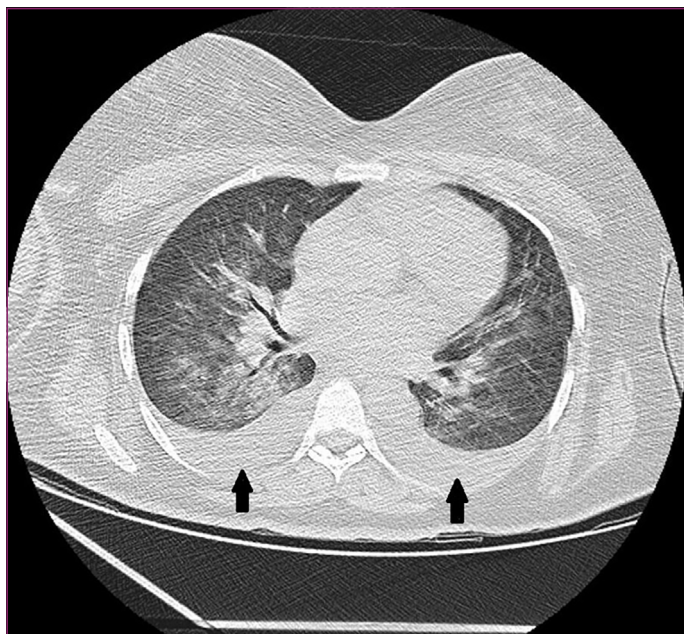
Preoperative thoracic computed tomography (CT) revealed bilateral pleural effusions measuring approximately 3 cm, without findings suggestive of COVID-19 pneumonia.
